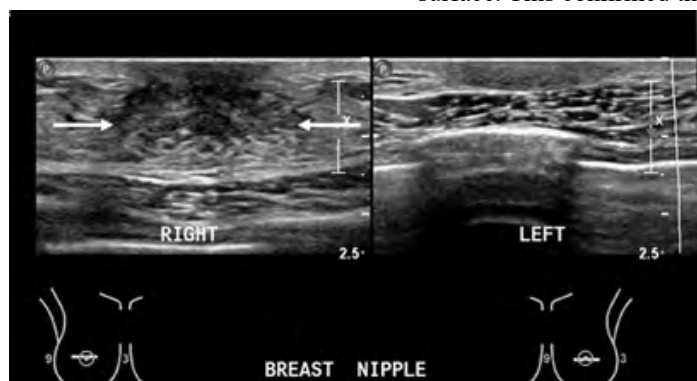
Ultrasound of bilateral breasts. Dense fibroglandular tissue (white arrows) is demonstrated in the right retroareolar region suggesting gynecomastia. Comparative left retroareolar region ultrasound image shows no similar tissue on the left side.
